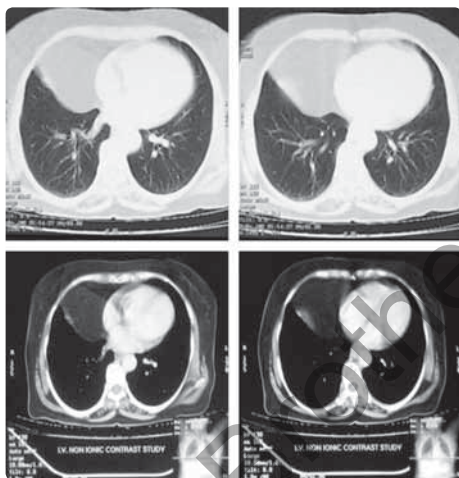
CT-thorax showing mass lesion in right cardiophrenic angle with fat density and loculation
